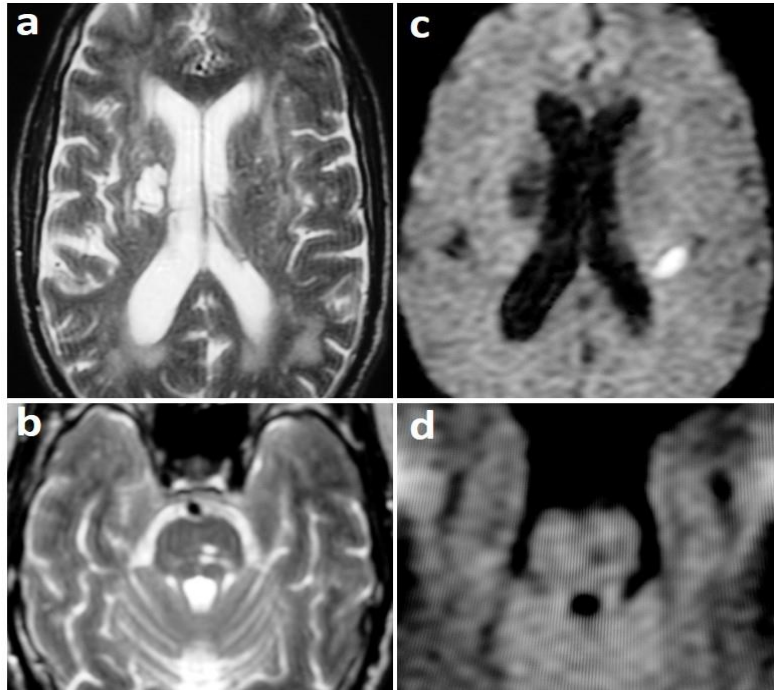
(a-d); Multiple ischemic infarctions of variable chronological ages mostly embolic in nature. (a&b) Axial T2WI; (c&d) Axial DWI-b1000. (1) Old ischemic infarctions at left pontine isthmus, right periventricular region exhibiting dark signals in DWI b1000 with hyper intense signal in T2WI. (2) Hyper acute ischemic infarction in the left parietal region exhibiting bright signal in DWI b1000, not visualized in T2WI.
